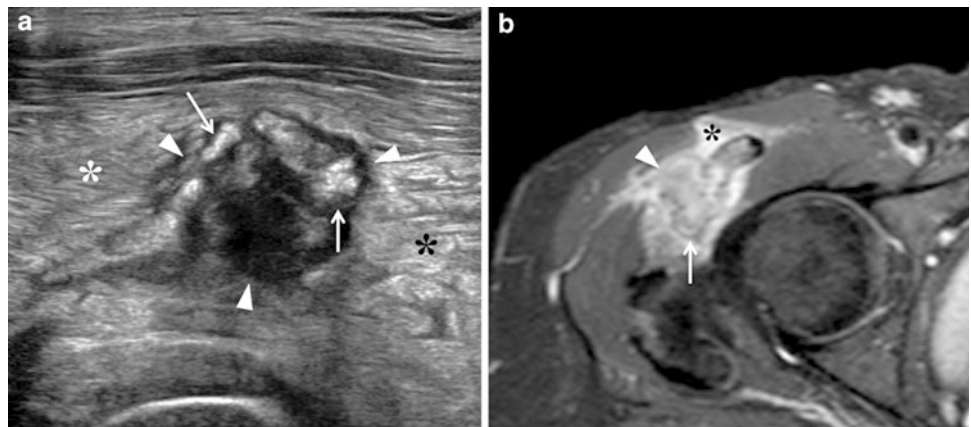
Myositis ossificans, early stage. a Transverse 12-5 MHz US image over the anterolateral right hip with b correlative fat-suppressed Turbo-Spin-Echo T2-weighted MR image demonstrates a heterogeneous soft-tissue mass (*arrowheads*) with peripheral calcified deposits (*arrows*) surrounded by intense inflammatory changes (*asterisks*). The calcific component of the mass is better visualized with US
